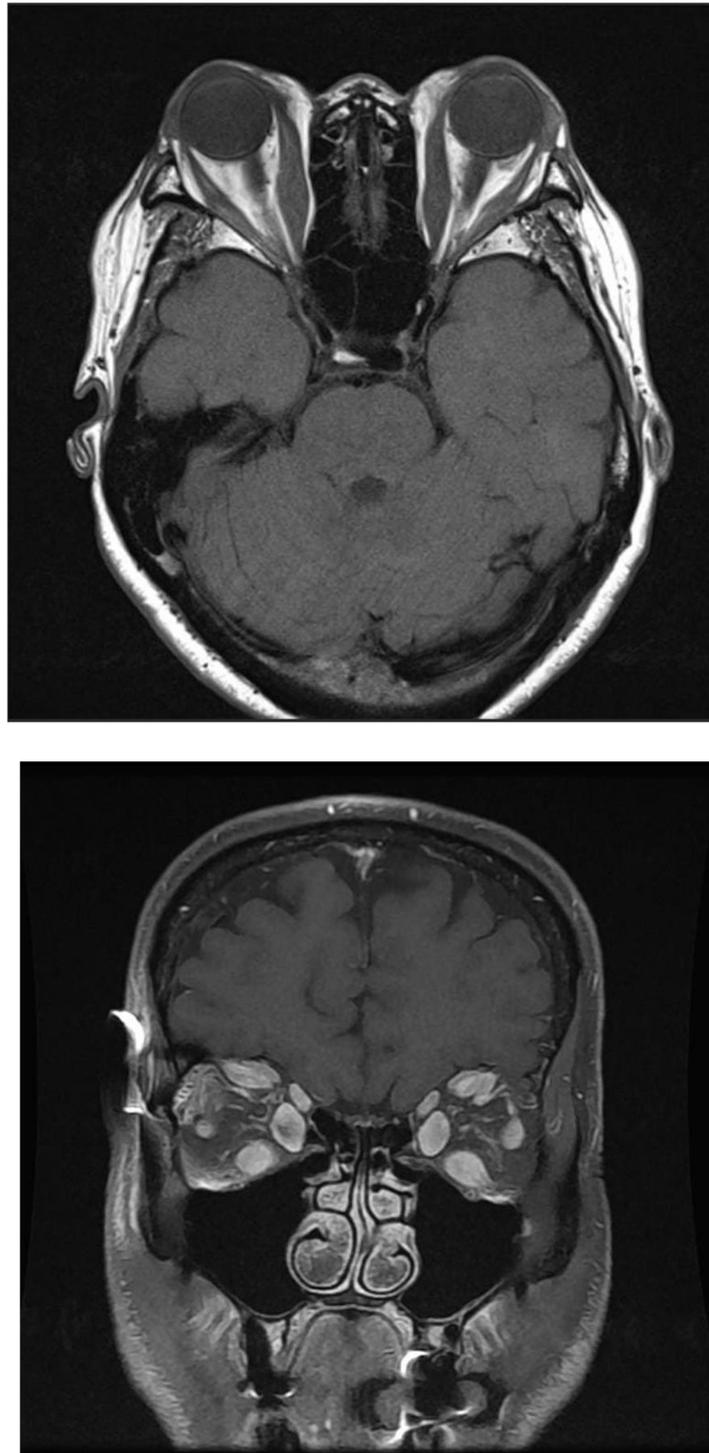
MRI ORBIT- Bilateral extra ocular muscles appears symmetrically thickened
